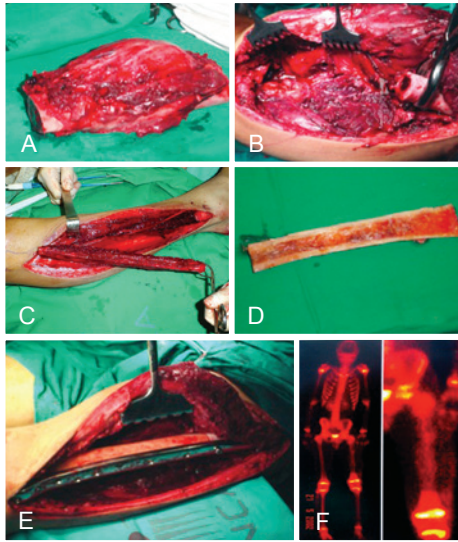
Case 2. In A, osteosarcoma of the left femur. In B, the receiving area. In C, the fibula flap. In D, allograft. In E, free fibula flap + allograft fixed by the receiving area. In F, perfusion scintigraphy performed on postoperative day 20 showing good perfusion of the flap and the allograft.
